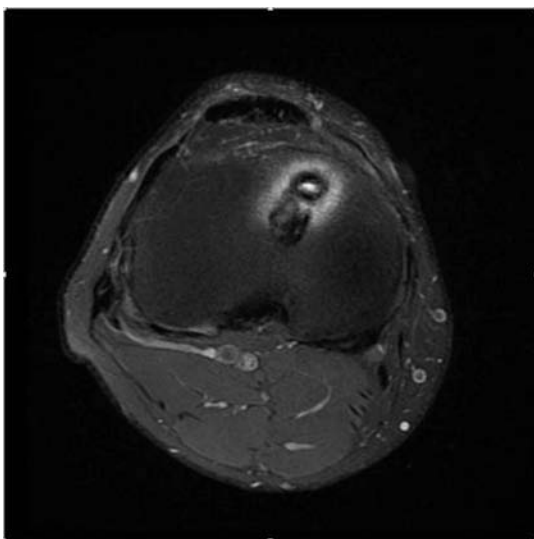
Axial MRI of the knee demonstrating the initial posterior lateral placement of the tibial tunnel and the more anteromedially placed augmentation graft.
